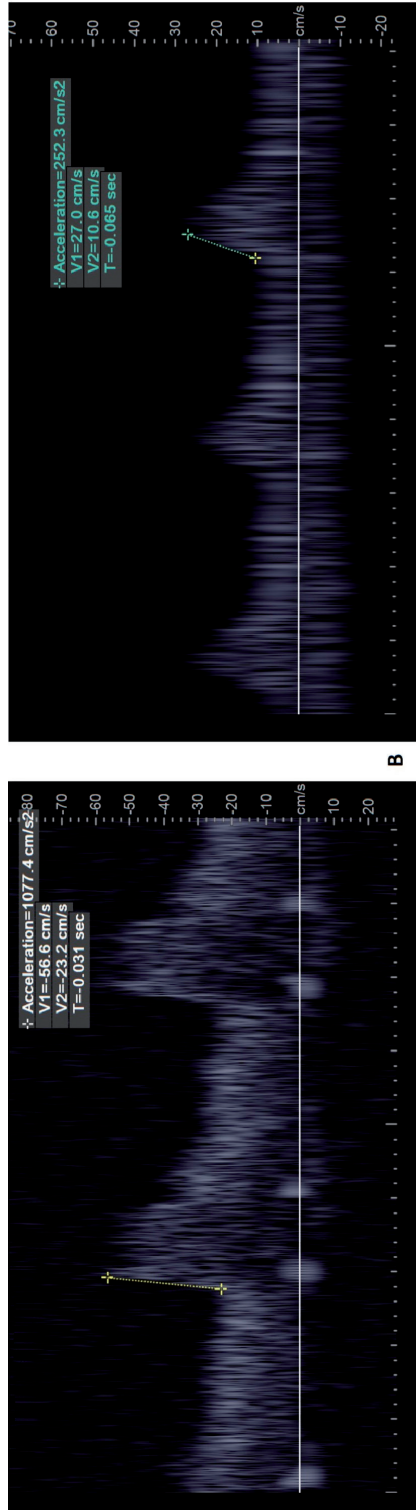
Doppler waveforms from the distal extracranial ICA. (A) a normal waveform is shown without a stenosis (ACCmax 10.8 m/s<sup>2</sup>); (B) a post stenotic signal at 70–99% ICA stenosis is obtained with a decreased ACCmax (2.5 m/s<sup>2</sup>). In both figures, the ACCmax is measured at the maximal slope in the systolic phase.
